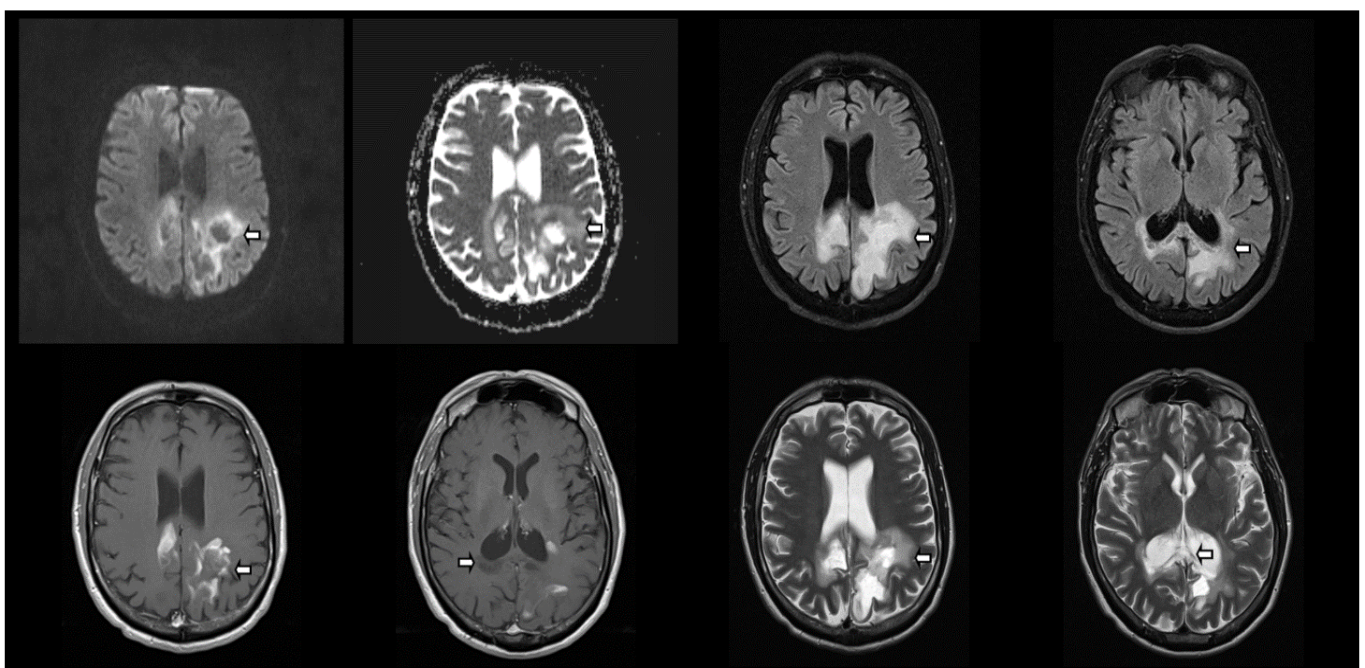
Three month follow-up brain MRI with provided DWI/ADC sequences (top left) demonstrate T2 shine through without restricted water diffusion (arrows) in the region of previously seen restricted water diffusion. FLAIR and T2 weighted sequences (top and bottom right) demonstrate necrosis and cystic change within the corpus callosum and subcortical white matter of the bilateral parietal lobes (arrows). T1 weighted post contrast sequence (bottom left) demonstrate resolution of the homogeneous enhancement with an incomplete, peripheral enhancement pattern.
